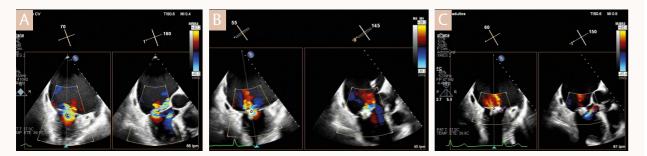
Transoesophageal echocardiography of the mitral valve pre procedure (A) and after one (B) and two (C) PASCAL Ace implants (bicommissural and X-plane views).
